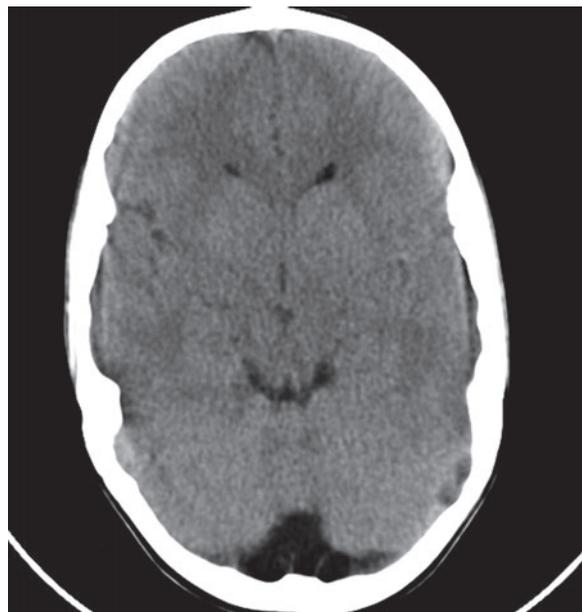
Mega Cisterna Magna (MCM), axial CT scan of another patient exhibits fluid collection located posteriorly to the cerebellar vermis and hemispheres. In the fluid collection, bifid cerebellar falx is seen.
